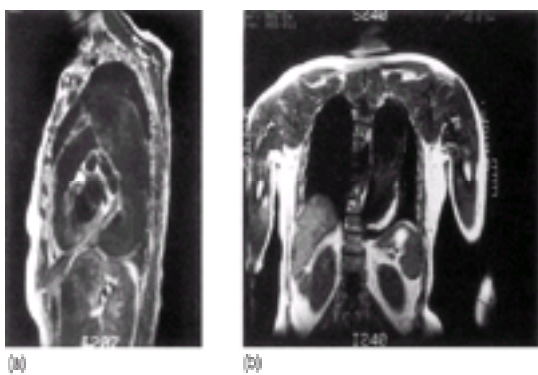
Oblique MRI section showing a normal ascending aorta together with a massive chronic type B aortic dissection.
